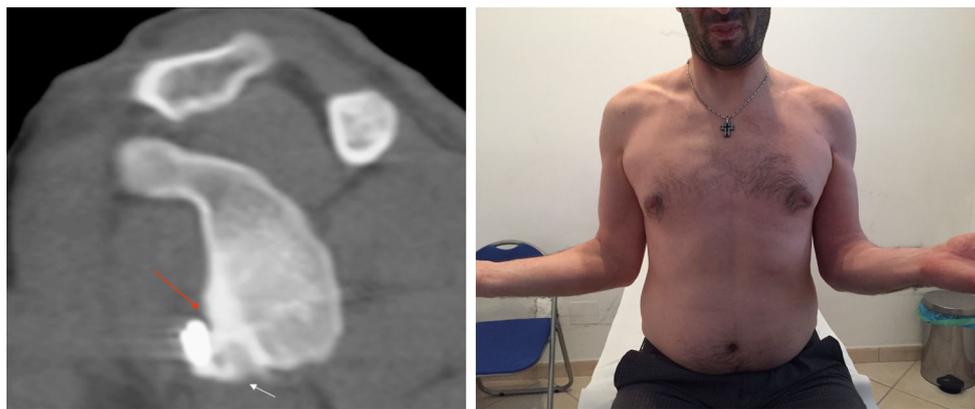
a A two years postoperative Pico CT scan with coracoid graft healed. b Clinical limitation of extrarotation (-15°)
